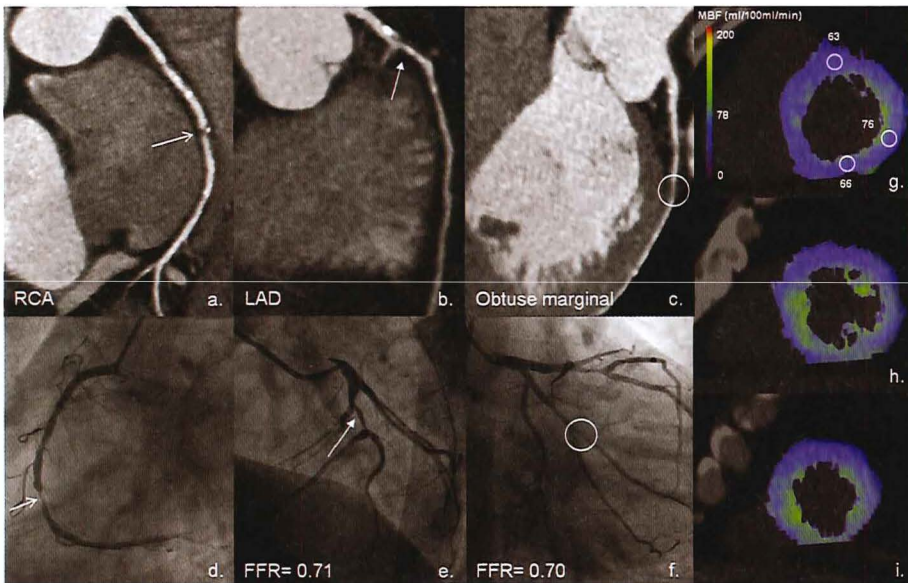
Dynamic CT perfusion imaging in a patient with 3-vessel disease.
